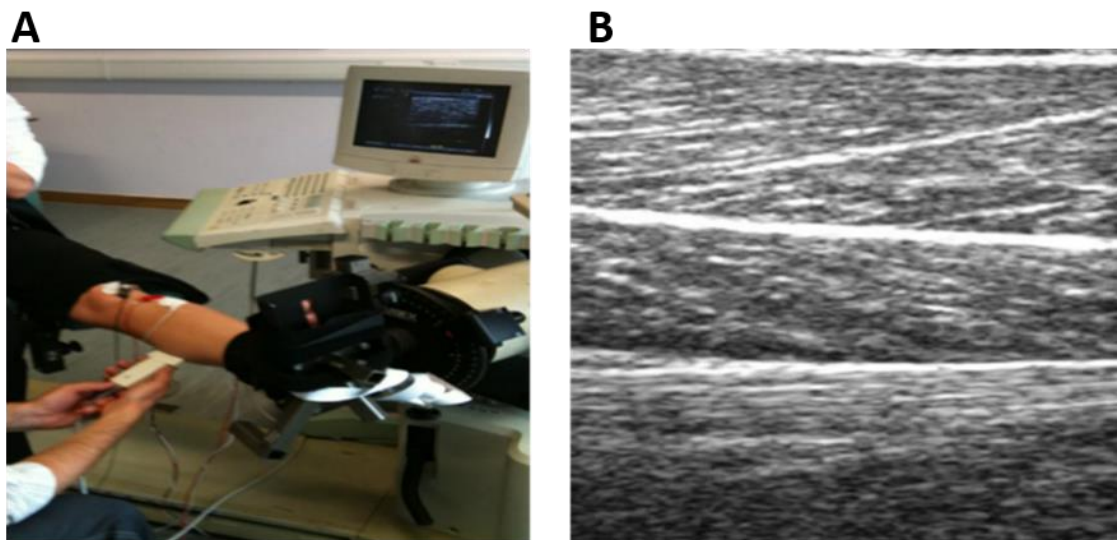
A) Application of ultrasound and equipment. B) Example of a greyscale image of the skeletal muscle fibres produced by the ultrasound scan when placed directly upon the skin
